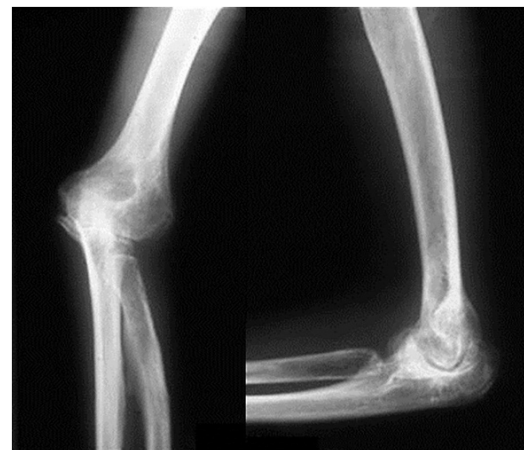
The X-rays of the left elbow 27 years after IPA-O
